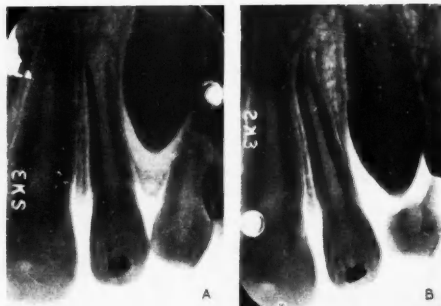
A, Radiograph shortly after the removal of the projection. B, Radiograph 2 years later, showing continued root formation.
